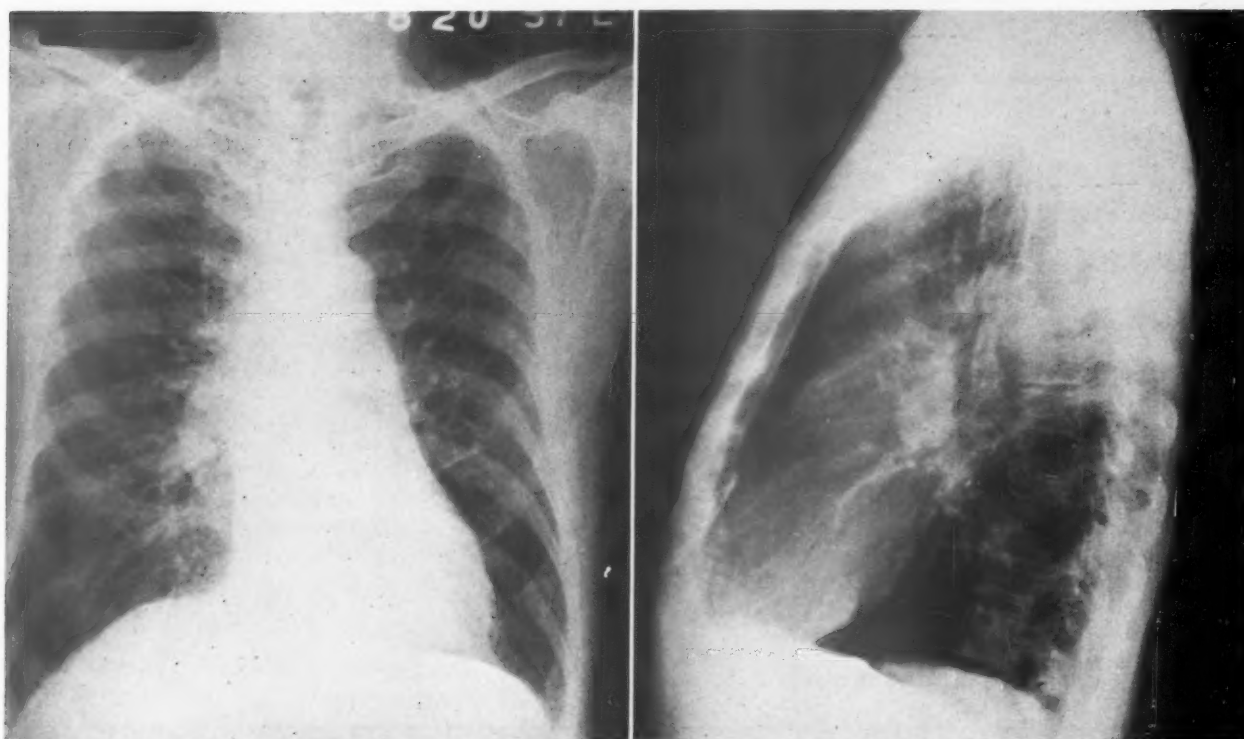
Posteroanterior and lateral roentgenograms of the chest showing slight cardiac enlargement and passive pulmonary congestion. No evidence of lung disease.
